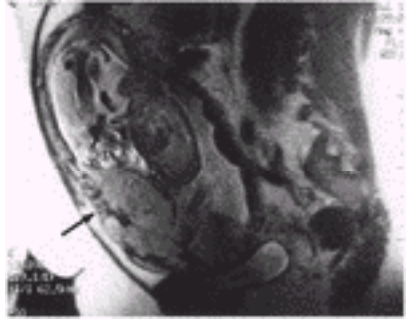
A sagittal T2-weighted magnetic resonance imaged case of placenta percreta. The percreta is low anterior (arrow). (Courtesy Dr. Mark Kliewer.)
